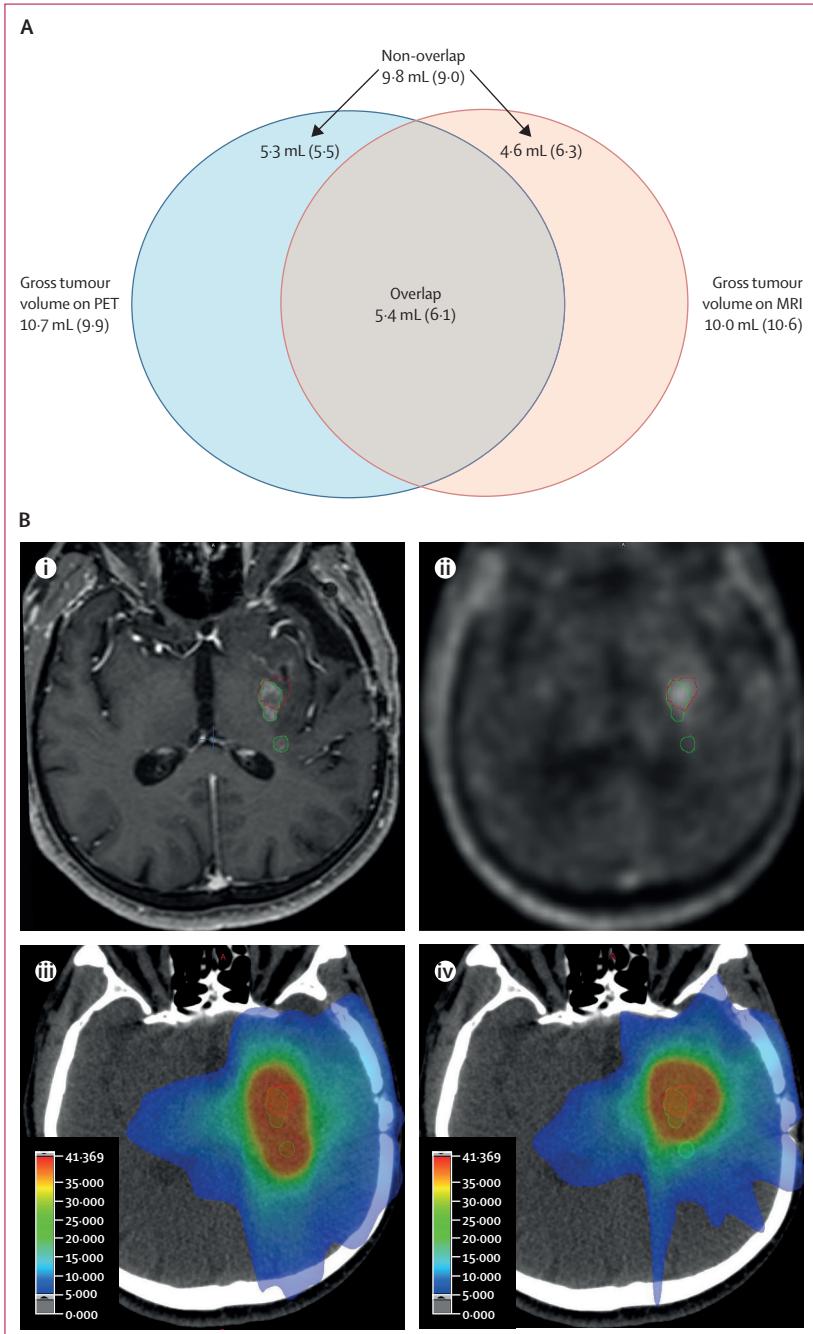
Spatial relationship of PET-based and MRI-based gross tumour volumes
